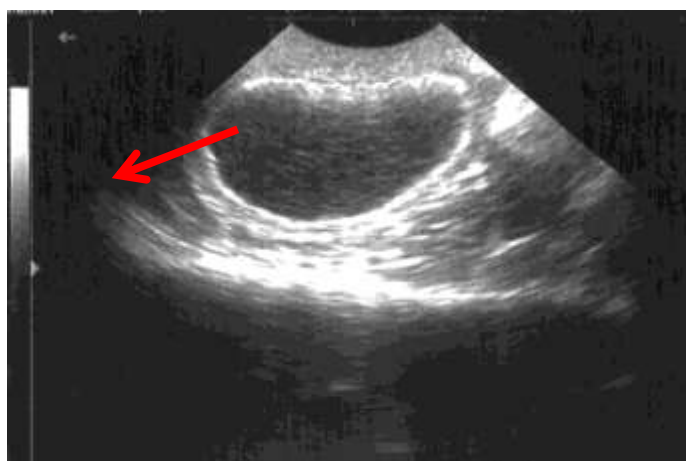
Ultrasound results showing the presence of hyperechoic particles in the urinary bladder (red arrow).
